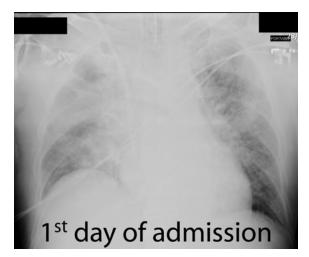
Chest roentgenogram on the third day of influenzalike illness or the first day of admission. Lung parenchyma shows bilateral ground-glass and reticular patterns of pulmonary infiltrates
